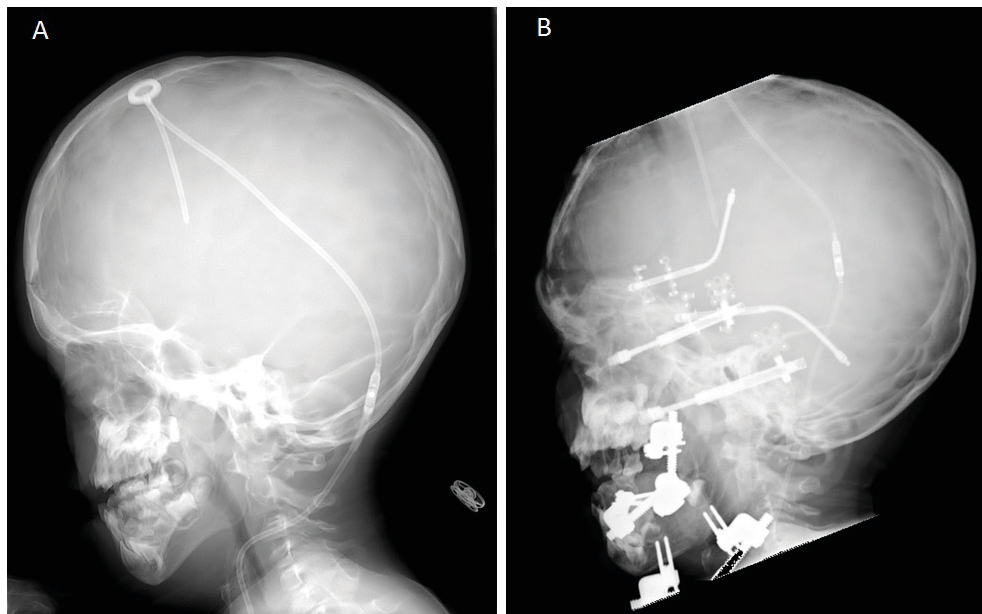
X-ray of a patient with midface and mandibular hypoplasia: A) pre-operatively; B) monobloc and mandibular advancement, during distraction. It should be noted that this patient had previously received a ventriculoperitoneal shunt at another hospital. Ventriculoperitoneal shunts reduce the driving force of skull growth. For this reason, we are reluctant to use shunts in young patients with craniosynostosis, and prefer skull expansion.
